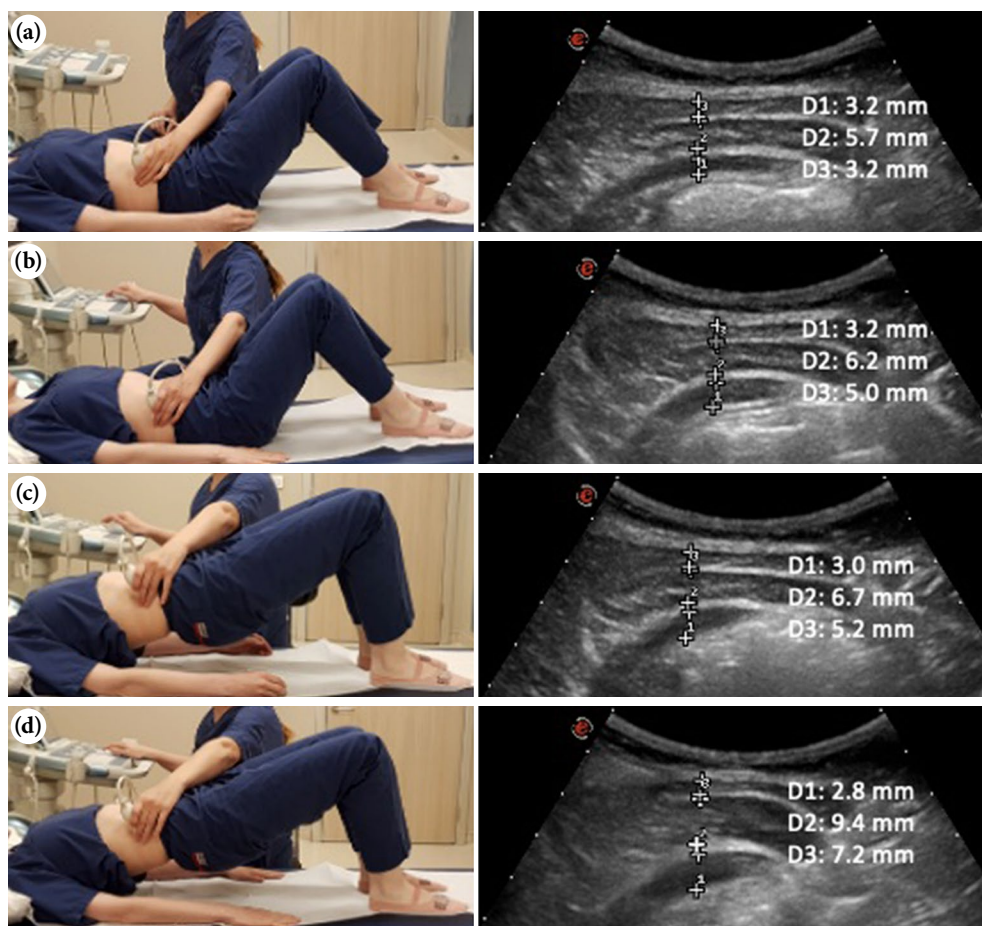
Positioning of the participant, placement of the transducer, and ultrasound images at rest during abdominal hollowing, bridge and bridge with isometric arm extension. (a) Rest. (b) Abdominal hollowing. (c) Bridge. (d) Bridge with isometric arm extension.
